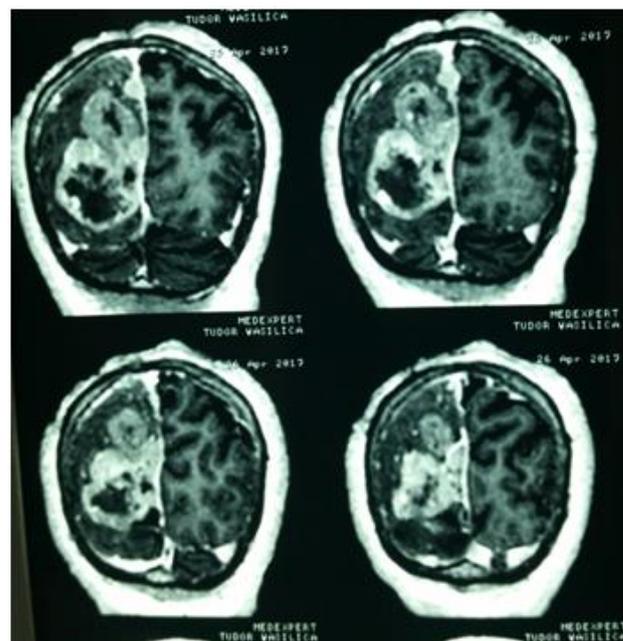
Preoperative enhanced CT- scan images, coronal view
